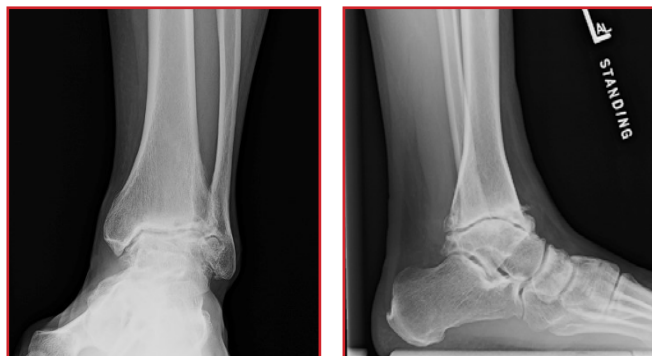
Preoperative radiographs of the left ankle joint, showing arthritic changes suggestive of hemophilic arthropathy, with loss of joint space and presence of osteophytes.
